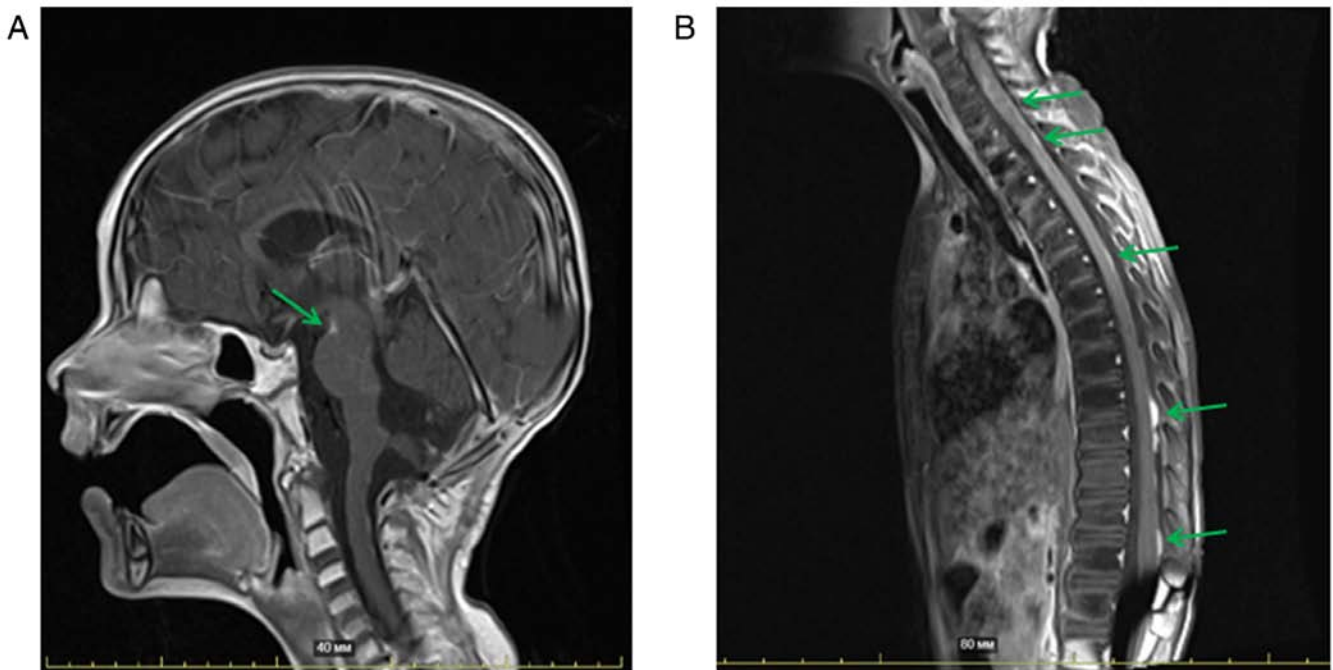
Central nervous system MRI of the patient at 3 months after discontinuation of the therapy. (A) Brain MRI (Sag T1 SE + C). Diffuse infiltration of the meninges of the cerebral hemispheres was observed in the area of the interpeduncular cistern with intensive contrast enhancement. Decrease in the size of the focus in the right occipital lobe (green arrow; scale bar, 40 mm). (B) Spinal cord MRI (Sag T1 TSE + C). Multiple metastatic lesions of the meninges of the spinal cord (C5, C7, Th5, Th9-Th10, L1) and signs of posterior subarachnoid space compression were observed at the level of Th9-Th10 with intensive contrast enhancement. A slight decrease in the size of the lesions at the level of C5 and Th5 was observed (green arrows; scale bar, 80 mm). Sag, sagittal.
